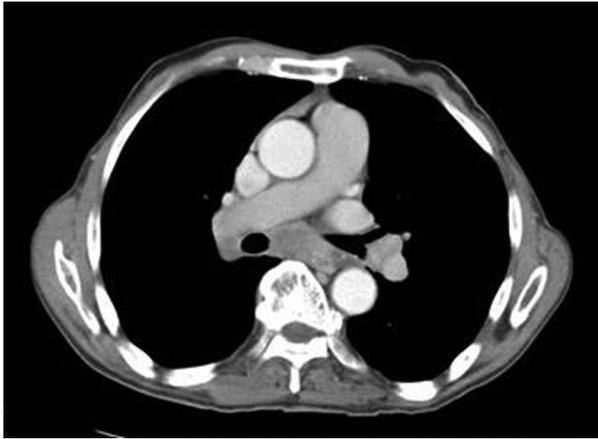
Chest CT scan shows subcarinal adenopathy; no lung nodules were seen. This was picked up by the patient’s pulmonologist and biopsy showed primary lung adenocarcinoma.
